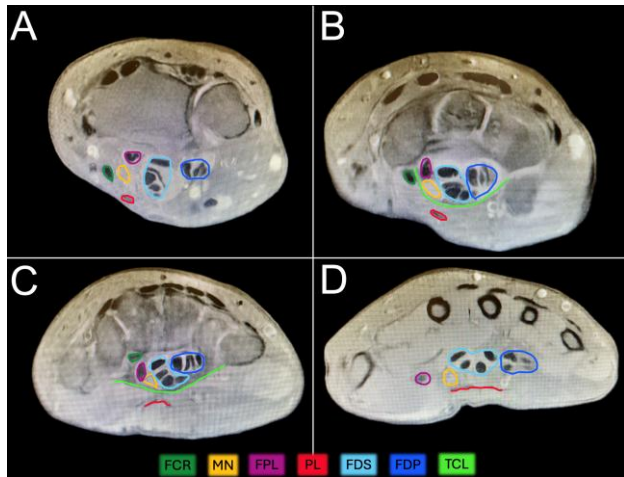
Preoperative MRI T1 fat suppressed axial cuts at different levels demonstrating extensive tenosynovitis in the carpal tunnel as shown by the hyperintense tissue around the flexor tendons. Different structures are outlined in color on each cut and detailed at bottom edge. (A) radiocarpal joint level, (B) proximal row level, (C) distal row level, and (D) metacarpal level.
